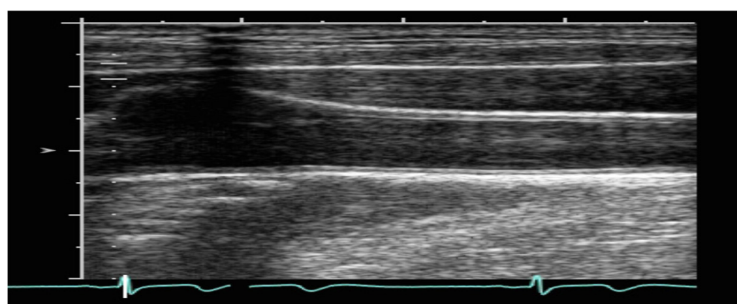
Showing the high-resolution ultrasound scan of carotid arteries
